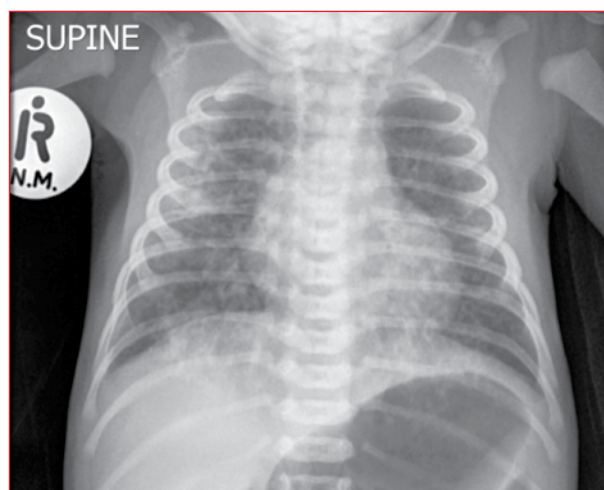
A chest X-ray with the typical appearance of meconium aspiration syndrome
